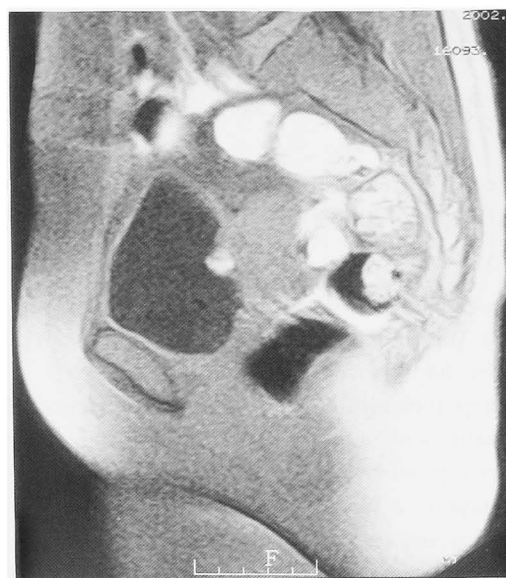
MRI (sagittal plane) showed a demarcated mass with a high signal intensity on T1-weighted images.
